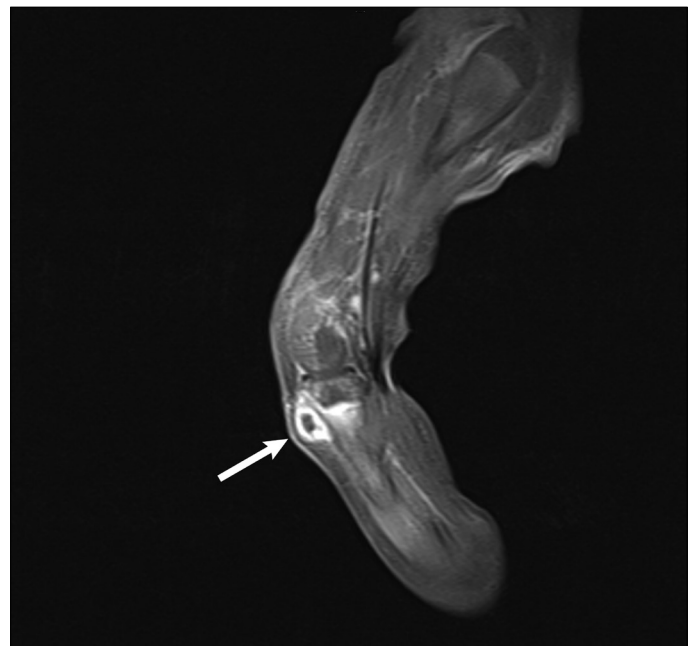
MR imaging of the knee showing enhancement and thickening in the prepatellar bursa
